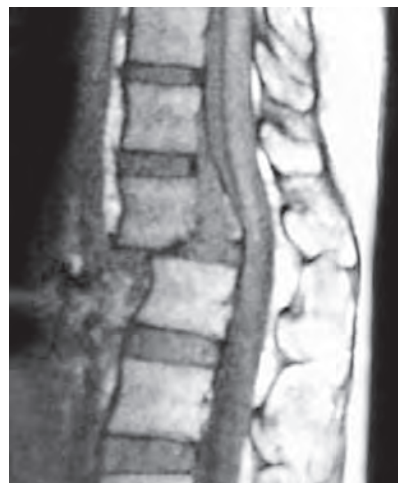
MRI showing dislocation of D12/LV1 due to missile injury
